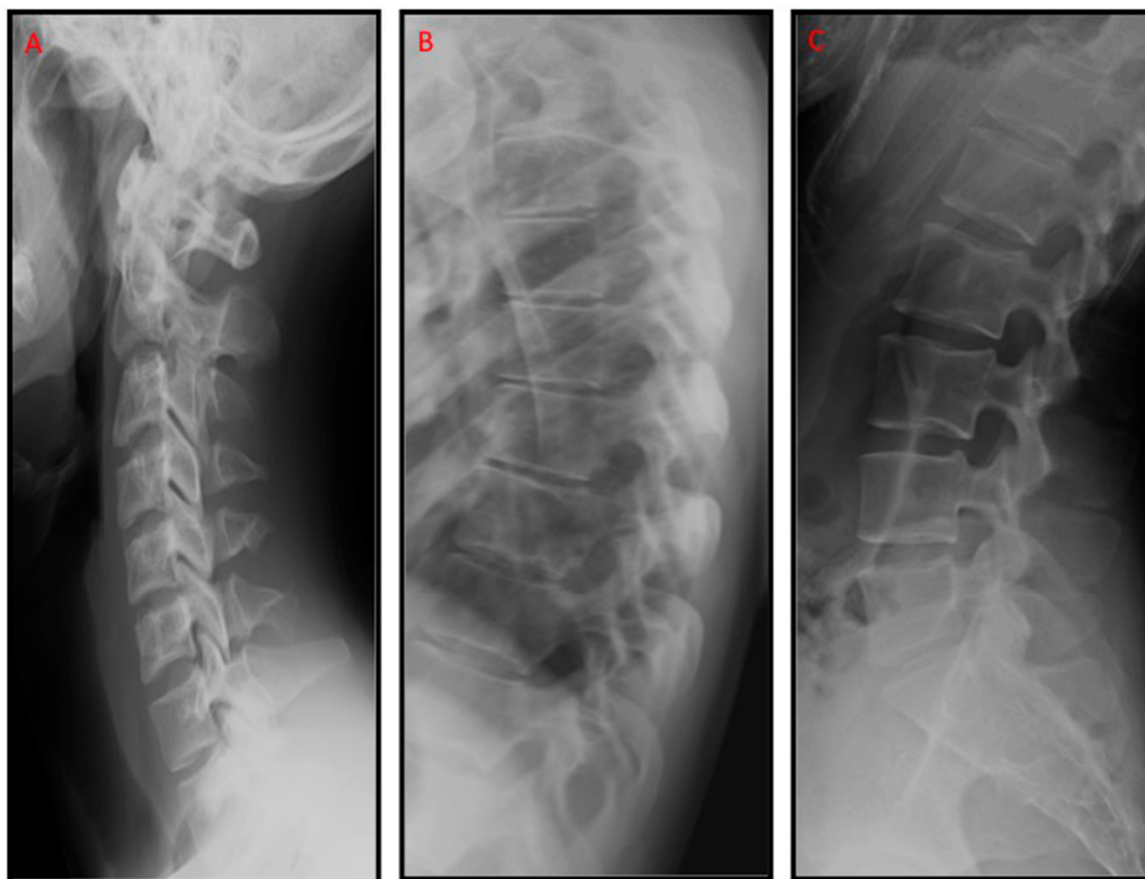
X-ray lateral projection of the spine. (A) Cervical curvature; (B) Thoracic curvature; and (C) Lumbar curvature.
